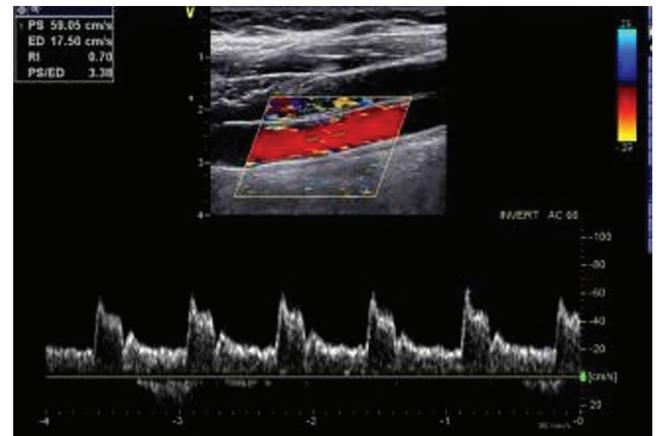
No abnormality in the color Doppler scan of cervical blood vessels.
